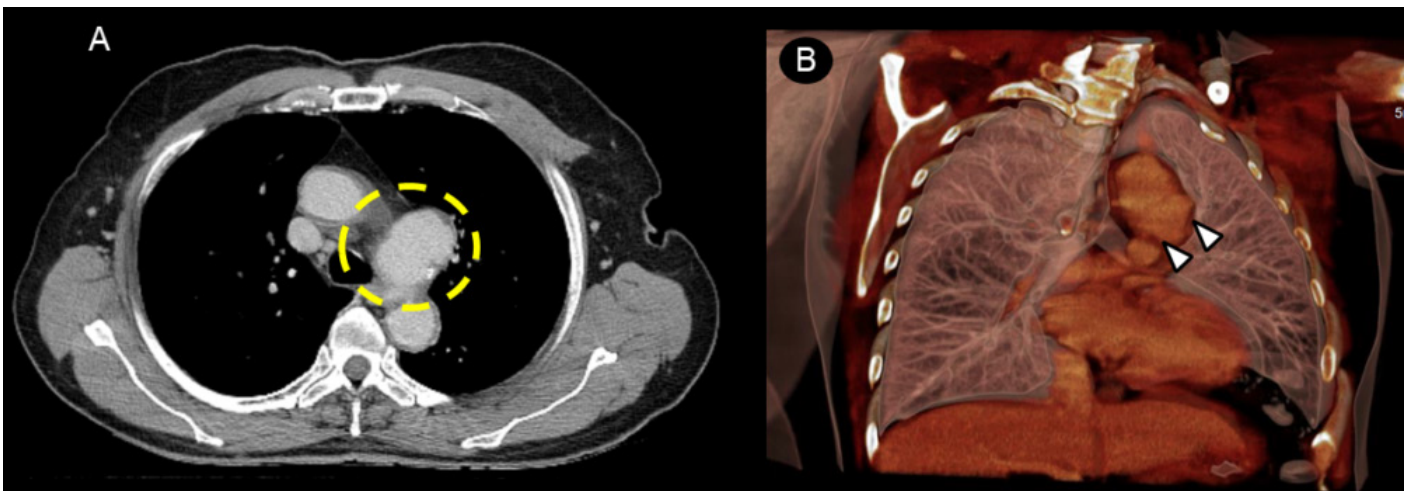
A chest computed tomography (CT) scan (A) in axial view demonstrate the presence of an aneurysm originating on the descending aorta, in close proximity to the origin of the left subclavian artery. The aneurysm extends inferiorly to the subaortic space (dashed yellow circle). Volume rendering reconstruction (B) in coronal view demonstrate the presence of a descending aorta aneurysm, which extends inferiorly to the subaortic space (white arrowheads).
